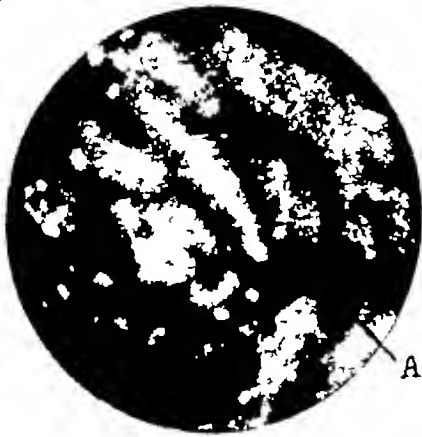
Here is shown the deformity of the rugæ from cicatricial contraction surrounding a small ulcer at A. Roentgen findings were rather uncertain.
